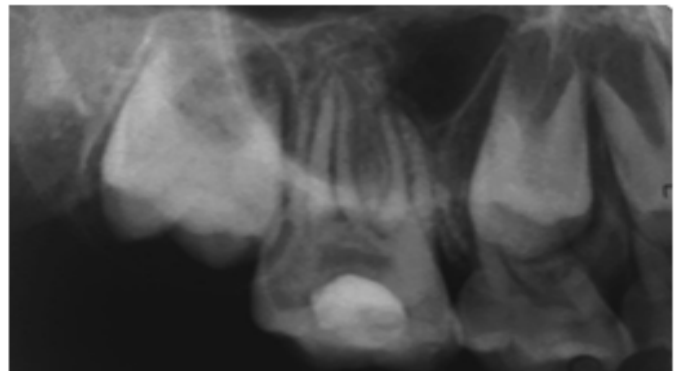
6 months follows up radiograph
